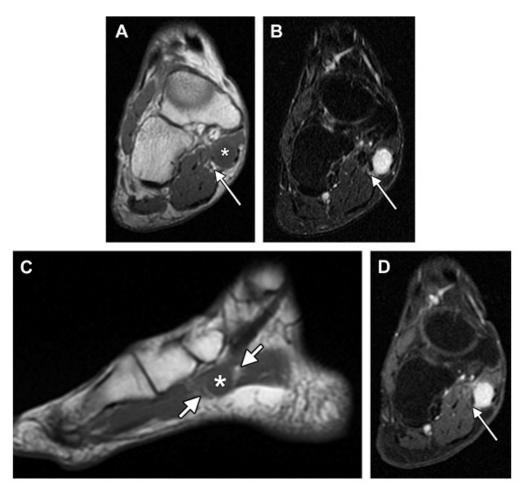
Schwannoma in a 56-year-old woman with a 6-month history of medial foot pain; Figure A - Short-axis T1-WI and Figure B - short tau inversion recovery images through the midfoot show a low to intermediate T1-weighted and intensely hyperintense T2-weighted mass (asterisk) located within the abductor hallucis muscle. The medial plantar nerve (arrows) is not involved, and no target sign is identified. Figure C - Sagittal T1-WI shows the low to intermediate signal mass (asterisk) surrounded by caps of fat (arrows), indicating slow growth. Figure D - Short-axis post contrast T1-WI with FS shows avid lesion enhancement mass and no involvement of medial plantar nerve (arrow).
